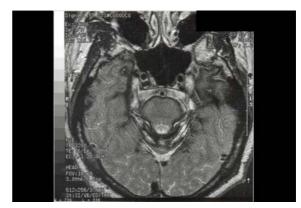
T2 weighted MRI shows low signal intensity on the surface of pons, medial temporal lobes and cerebellar folia, and along the trigeminal nerves
